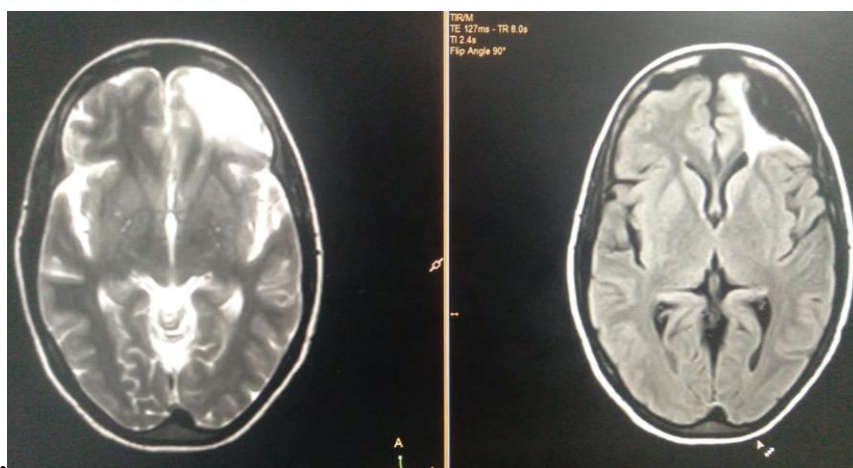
Axial T2 and b. Axial T2/FLAIR sequences showing area of encephalomalacia with surrounding gliosis in left frontal lobe.
